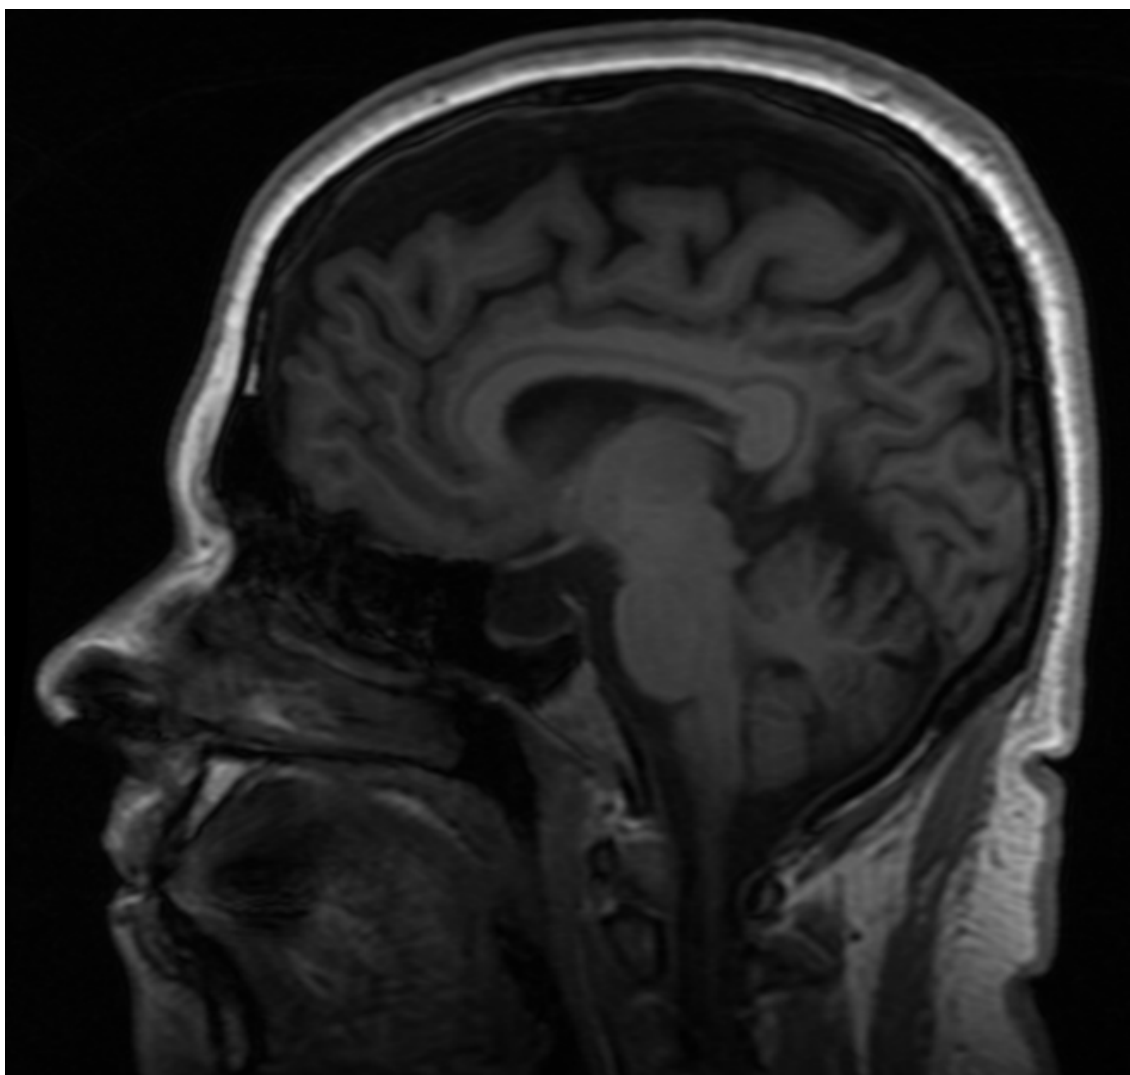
MRI image demonstrating an empty sella in a 26 year old PTC patient
